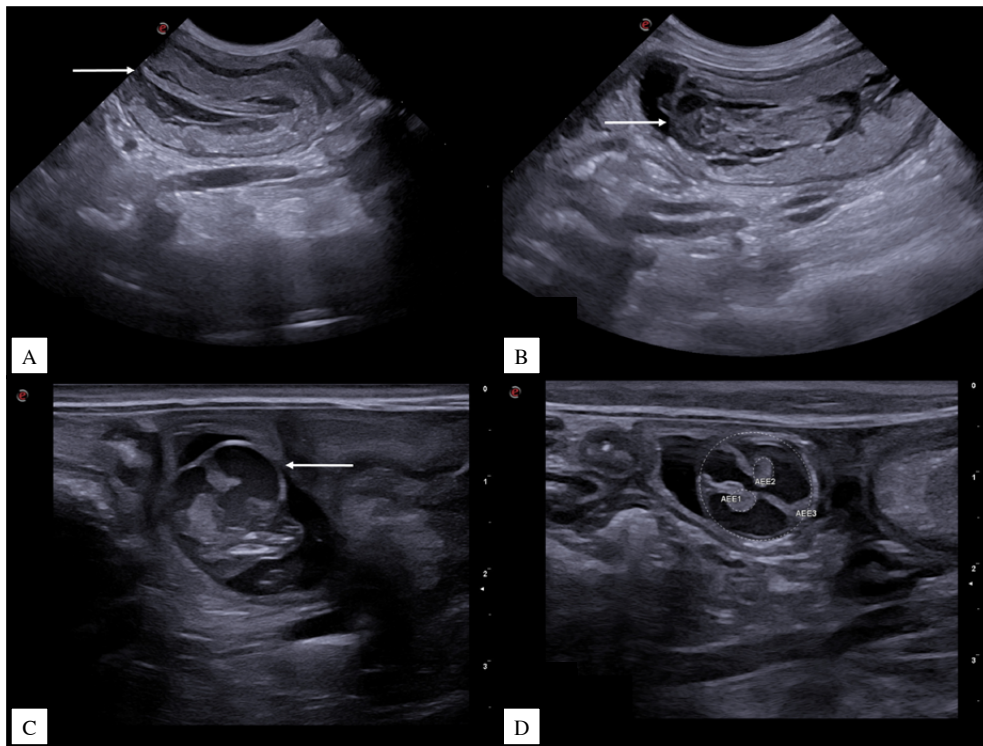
Abdominal ultrasound evaluation in B-mode showing a thickened, irregular uterus with heterogeneous echogenic content in the left uterine horn (A & B), suggestive of embryonic absorption; right uterine horn with an altered but still viable fetus (C & D). Bulging skull conformation, thinning of the cortical bone in the skull and increased intracranial volume, with a hypoechoic appearance and interspersed echogenic material are also noted in (C). Echobiometry of the fetal cranium in transventricular section with measurement of the brain mass area [area of the cerebral hemispheres = AEE1 and AEE2 = 0.05 cm² each] and area of the cranium [AEE3 = 1.13 cm²] can be assessed in (D).
